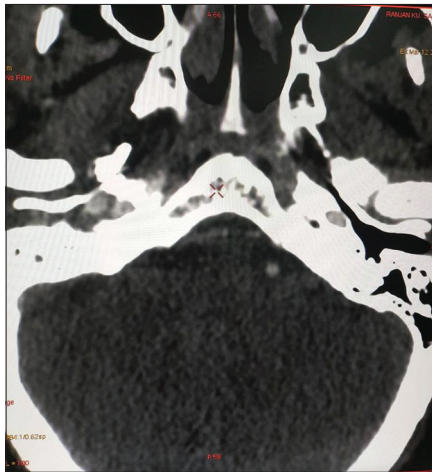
Computed tomography temporal bone shows mass in the middle ear
